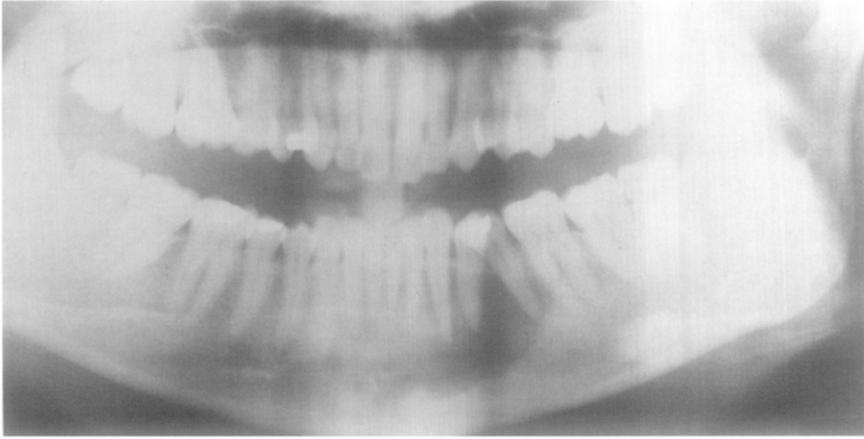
Case 5. Radiograph shows loss of bone in the area 42–35 suggesting a "hanging in the air" appearance of the involved teeth.
